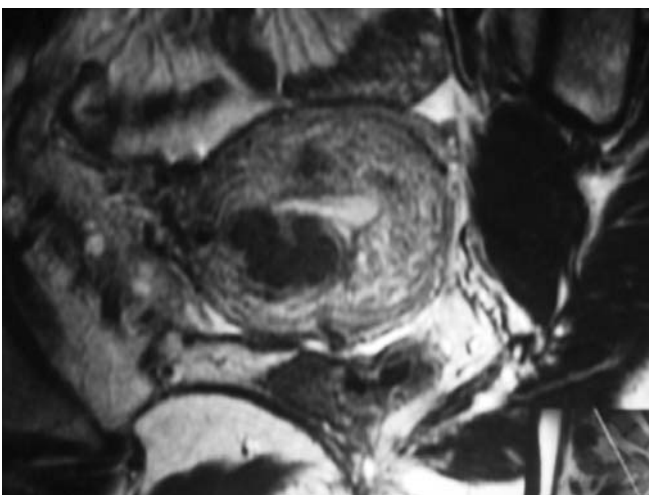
MRI of 23 mm submucous fibroid with intramural component
